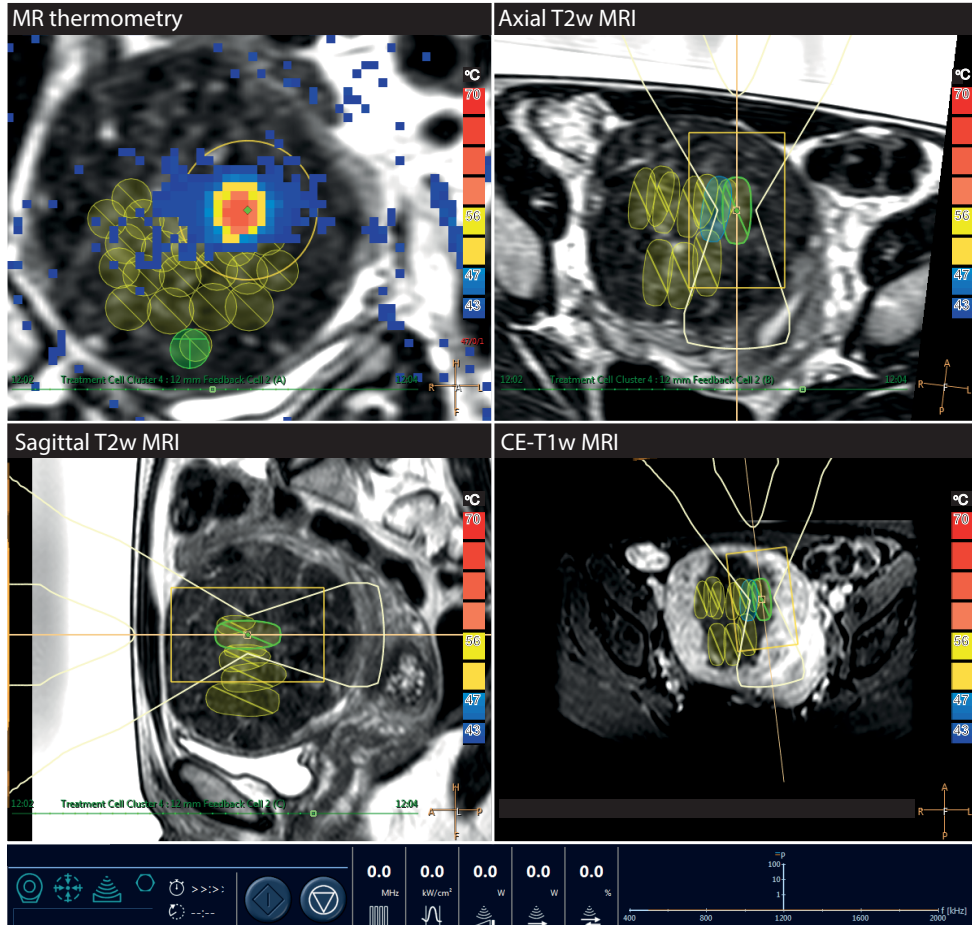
Typical representation of the MR images in the MR-HIFU user interface during treatment of uterine fibroids. The patient was lying in prone position (feet first) on the MR table top with the integrated direct skin cooling (DISC) device. The uterine fibroid was positioned directly above the MR-HIFU transducer. The ultrasound beam path was planned using T2-weighted MRI in three orthogonal planes, i.e. coronal (top left), axial (top right) and sagittal (bottom left) plane. During each sonication, colour temperature maps were computed by the MR-HIFU system using the proton resonance frequency shift (PRFS) thermometry method, and shown on top of the anatomical images (top left). Immediately after MR-HIFU treatment, the volume that was successfully treated was defined as the non-enhancing part of the fibroid on contrast-enhanced T1-weighted MRI (bottom right).
